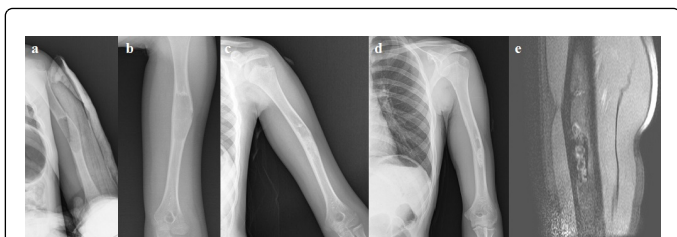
An 11-year-old male patient with bone cyst first admitted with pathological fracture, a. Long arm splint was applied to stabilize the fracture; b. Control image (2nd month); c. Control image (1st year); d. Control image (3rd year); e. MRI (3rd year).
